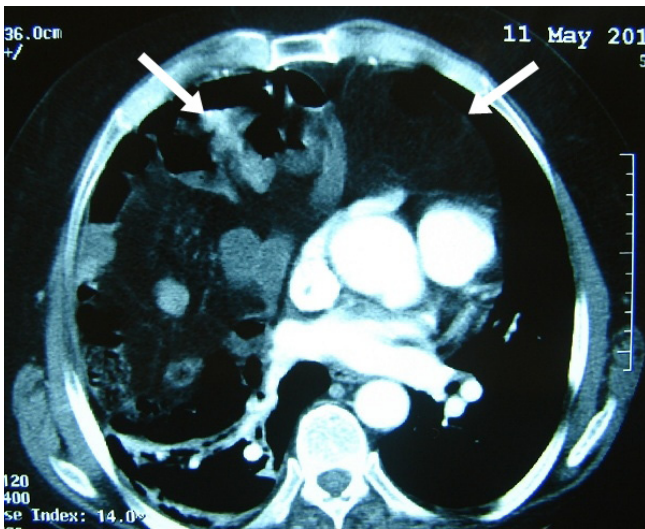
View of the intraabdominal content herniated to the thorax at both side in the retrosternal area on CT sections
